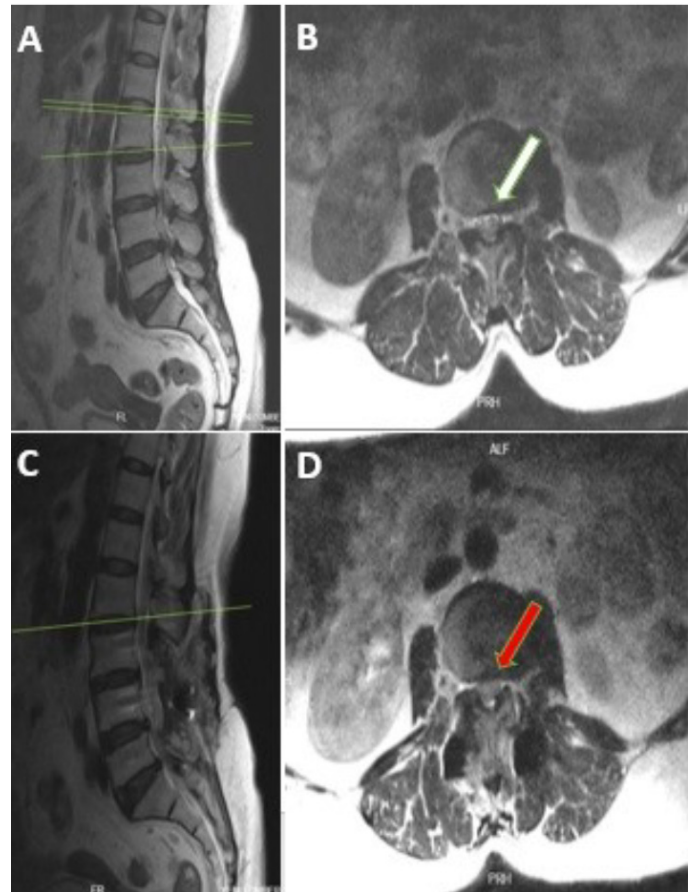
A and B, preoperative sagittal and axial lumbar T2 MRI. A 63-year-old female patient underwent lumbar decompression and fusion surgery for L3-L5 spinal stenosis. C and D, postoperative sagittal and axial lumbar T2 MRI. A hybrid rod was used during the operation. The patient presented with mild low back pain at the postoperative 18th month. In the lumbar MRI, there was no apparent adjacent segment disease in the upper segments. White arrow: Canal diameter at L2-L3 level in the preoperative period. Red arrow: Canal diameter at L2-L3 level in the postoperative period.
